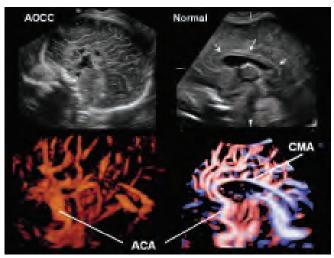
Agenesis of the corpus callosum (AOCC). (left upper) Midsagittal section in a case of AOCC. Typical radial sulcus formation is seen instead of normal cingulate sulcus and gyrus formed with normal development of the corpus callosum (arrows) seen in the upper right figure. (lower left) Angiostructure by 3D power Doppler. Normal callosomarginal artery (CMA, lower right) does not exist and radial formation of the branches of anterior cerebral arteries (ACA) is seen
